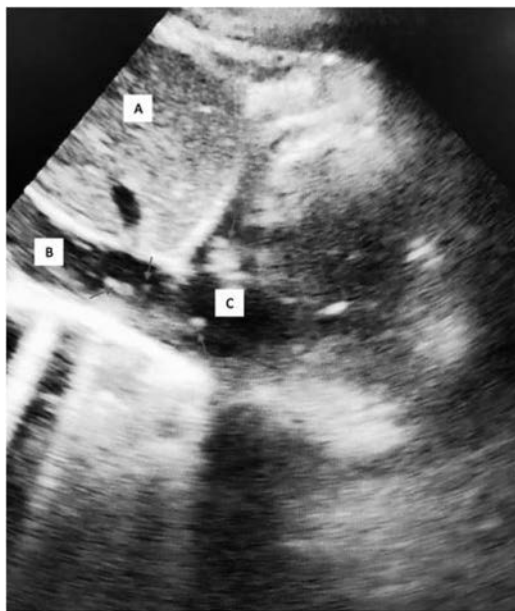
Point-of-care ultrasound echocardiogram with subxiphoid view. The liver (A), IVC (B) and inferior cavoatrial junction (C) are seen. Air bubbles are noted within the IVC and inferior cavoatrial junction (red arrows).
